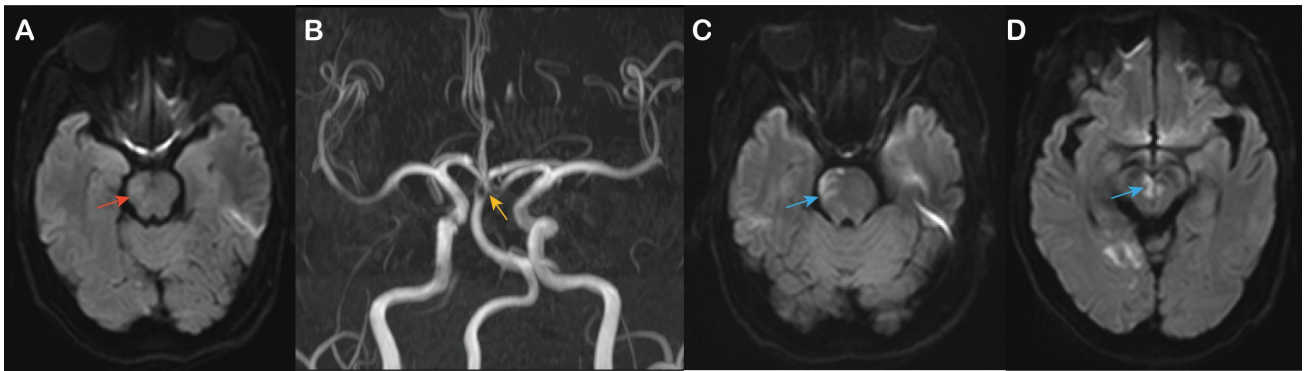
Neuroimaging following in-hospital neurological deterioration. (A) Re-examination of diffusion-weighted imaging (DWI) sequences in 5 h after loss of consciousness during hospitalization suggested an acute infarction in the right cerebral peduncle (red arrow). (B) Magnetic resonance angiography on 17 August showed a newly-formed thromboembolic occlusion of the top of the basilar artery (yellow arrow). (C,D) DWI sequences on 17 August confirmed new acute infarctions in the right pontine and the red nucleus (blue arrows).
